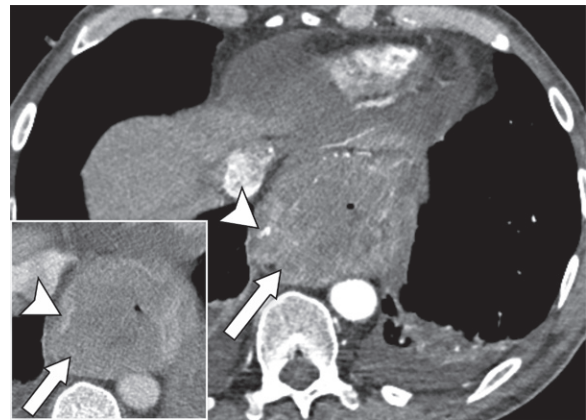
Esophageal neuroendocrine tumor (NET) with active bleeding in a 48-year-old man who presented with hematemesis. Axial arterial phase (main image) and 75-second venous phase (inset) CTA images show a large heterogeneously enhancing distal esophageal mass (arrows in both images), with a focus of contrast extravasation in the arterial phase (arrowhead in main image) that changes in size, attenuation, and shape in the venous phase (arrowhead in inset). Endoscopic biopsy performed 1 month earlier allowed confirmation of a poorly differentiated NET.
